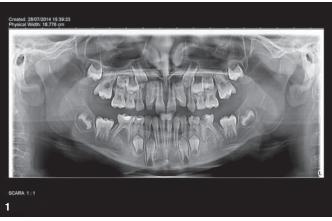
Initial situation, panoramic radiograph. Fig. 2: Initial situation, clinical photograph.
